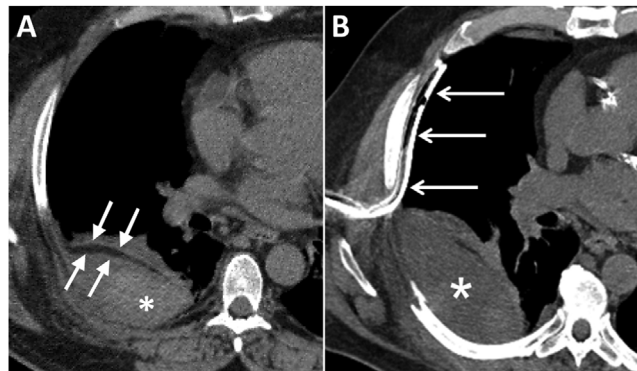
Alcoholic patient who fell downstairs. Axial images of non-contrast CT, mediastinal window (A-B). (A) Extrapleural linear fat (arrows) is seen between the haematoma (asterisk) and the lung. These findings were initially interpreted as a haemothorax, and so a drainage tube was placed (arrows in B) but was not effective. In fact, the tube was unable to penetrate the extrapleural haematoma (asterisk). The patient also had rib fractures.
